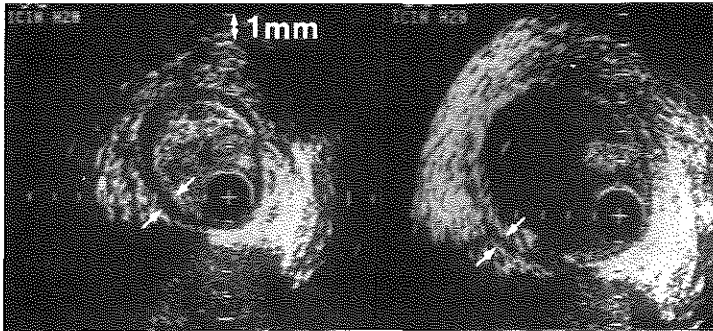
Intravascular ultrasound cross sections obtained at the same level before (left panel) and after (right panel) balloon angioplasty showing an increase in free lumen and media-bounded areas associated with a decrease in media thickness after intervention (arrows). Embolectomy before the balloon angioplasty in this surgical patient has evidenced thrombus. Calibration=1 mm.
